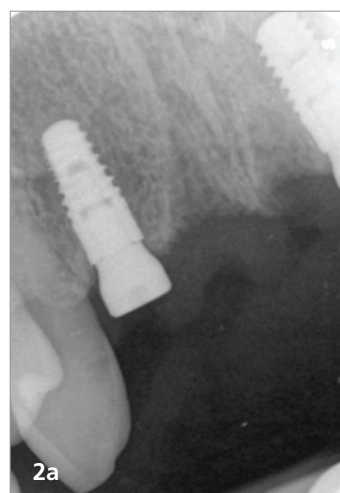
Panoramic radiograph. Chronic periodontitis with hopeless maxillary incisors. Figs. 2a & b: Control radiograph after immediate implantation with healing abutments in place (narrowSky, diameter 3.5 mm, length 10 mm; bredent medical).
